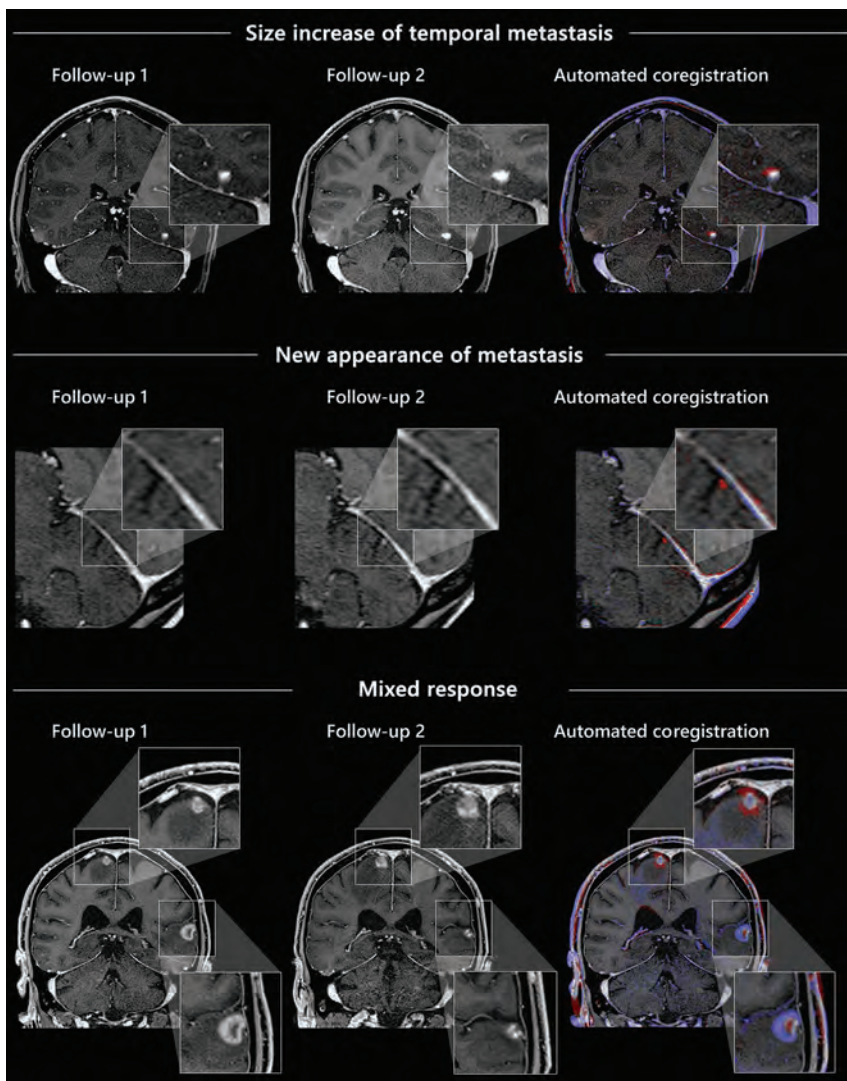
Examples of the automated coregistration of follow-up examinations and color-coding of longitudinal changes in contrast-enhanced, T1-weighted 3D sequences.
